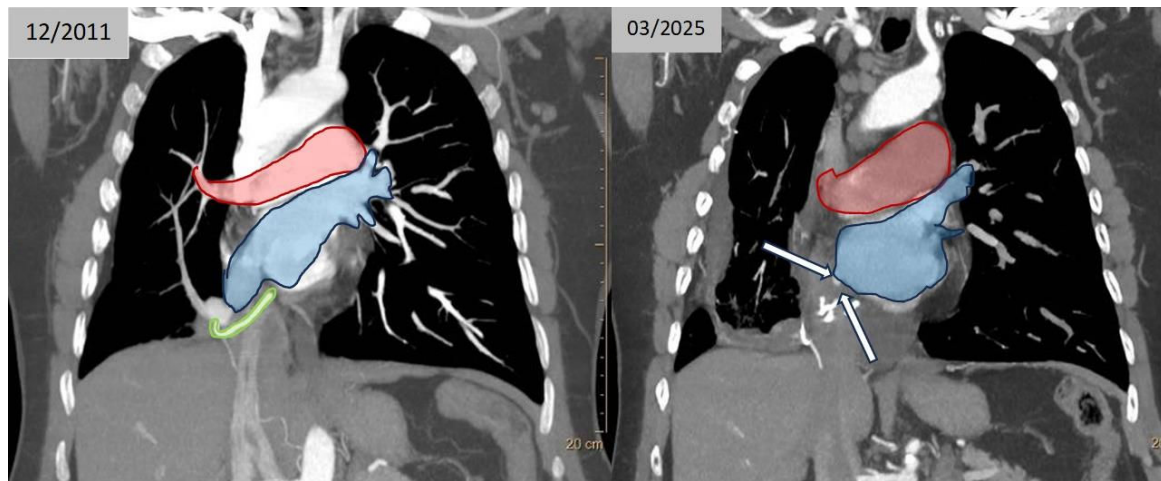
Contrast-enhanced chest CT scan demonstrating right pulmonary venous drainage correction through pericardial patch (first image) and its complete occlusion (second image). Red: left circulation; Blue: right circulation. Green: pericardial patch conduit connecting to the left atrium via the atrial septal defect.
